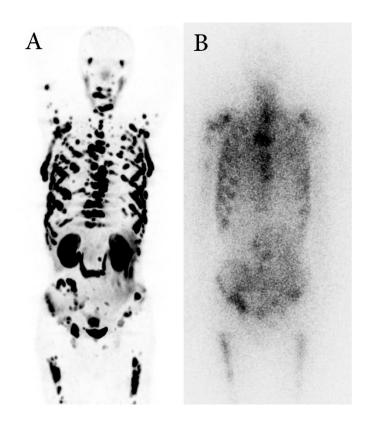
A 65-year-old man with a history of de novo metastatic prostate cancer (Gleason score = 9). He had refractory bone pain in the pelvic region. The [68 Ga]Ga-Postate-specific membrane antigen positron emission tomography ([68 Ga]Ga-PSMA PET) shows widespread bone metastases (A). Prostate-specific antigen level (PSA) was 14 ng/mL before [177 Lu]Lu-PSMA therapy, which declined to 3.65 ng/mL after the first cycle. Post-treatment [177 Lu]Lu-PSMA whole body scan reveals good targeting of the [177 Lu]Lu-PSMA in the metastatic lesions (B).
